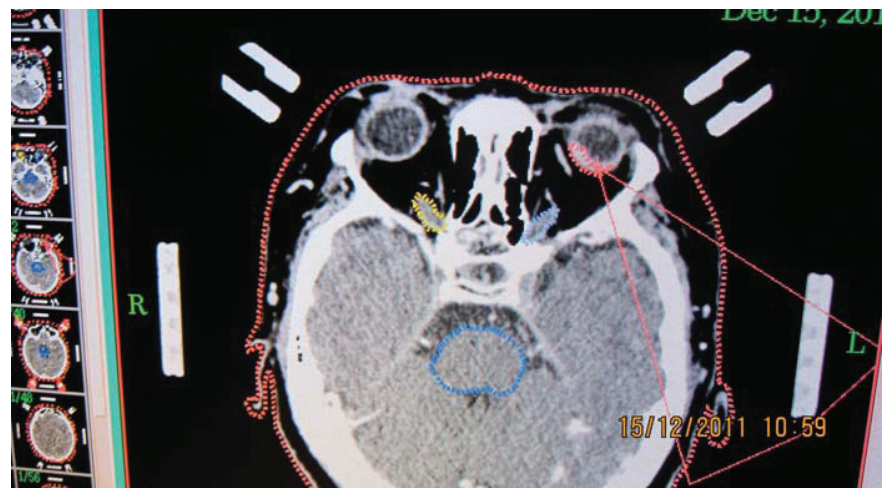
CT image of patient with mounted stereotactic frame – tumour deposit indicated in red
